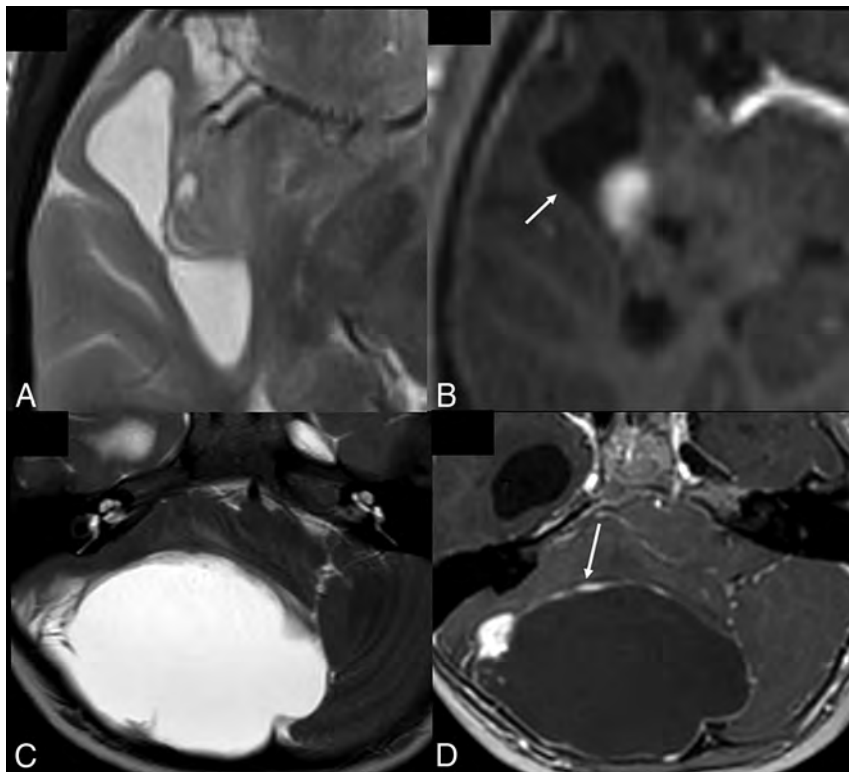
Cysts in pediatric intracranial tumors. A and B, BRAF V600E-positive astrocytoma. Axial T2-weighted and contrast-enhanced axial T1-weighted images show a dominant cyst with an enhancing mural nodule. The cyst wall does not enhance (arrow). C and D, Pilocytic astrocytoma. Axial T2-weighted and contrast-enhanced axial T1-weighted images show a dominant cyst with an enhancing mural nodule. The cyst wall enhances (arrow).
